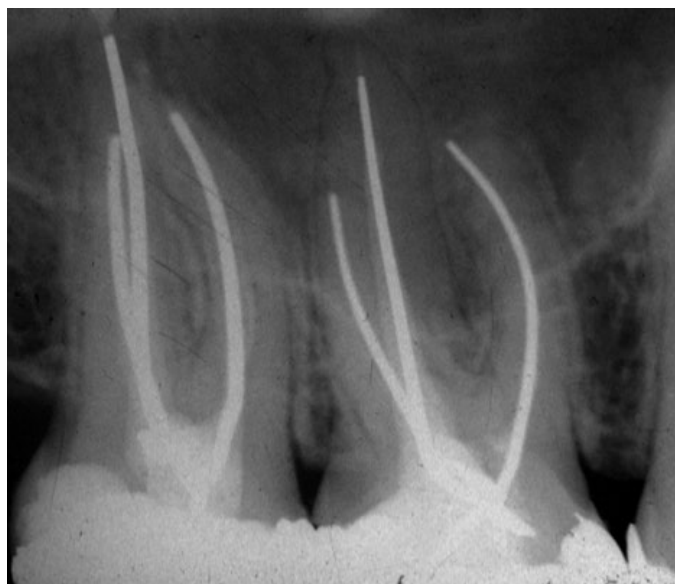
(A) Thirty-five years post root canal therapy. Teeth asymptomatic and no radiographic changes.
